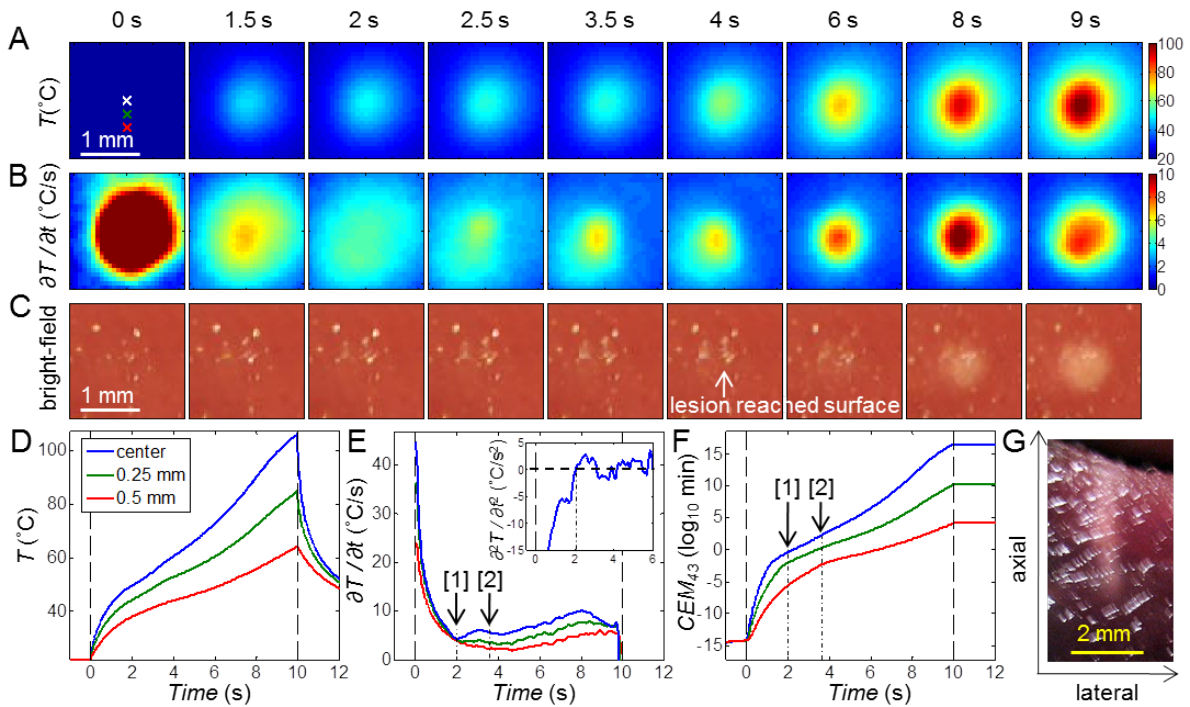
Ablative HIFU exposures (1060 W/cm^2 , 10 s duration) with the focus placed at 3 mm beneath the surface. (A) IR images showing the surface temperature T ($^{\circ}\text{C}$). (B) Images of the rate of temperature change $\partial T/\partial t$ ($^{\circ}\text{C/s}$). (C) Bright-field images of the tissue surface showing lesion formation. (D) Time evolution of T at the center and 0.25 mm and 0.5 mm below the center (indicated on the first IR image in (A)). (E) Corresponding time evolution of $\partial T/\partial t$: [1] $\partial T/\partial t$ starts to increase at 2 s, suggesting lesion formation in subsurface; [2] The CEM_{43} reaches 170 min at 3.62 s, predicting lesion formation at the surface between 3.5 and 4 s (see frame with arrow in (C)). The upper-right box shows the time evolution of $\partial^2 T/\partial t^2$ ($^{\circ}\text{C/s}^2$) at the center. The first zero-crossing occurred at 2 s. (F) Corresponding time evolution of CEM_{43} : [1] 0.42 min at 2 s; [2] 170 min at 3.62 s. (G) Gross image of the lesion cross-section. Axial is the direction which ultrasound beams propagated, from the bottom surface of the tissue to the top surface.
